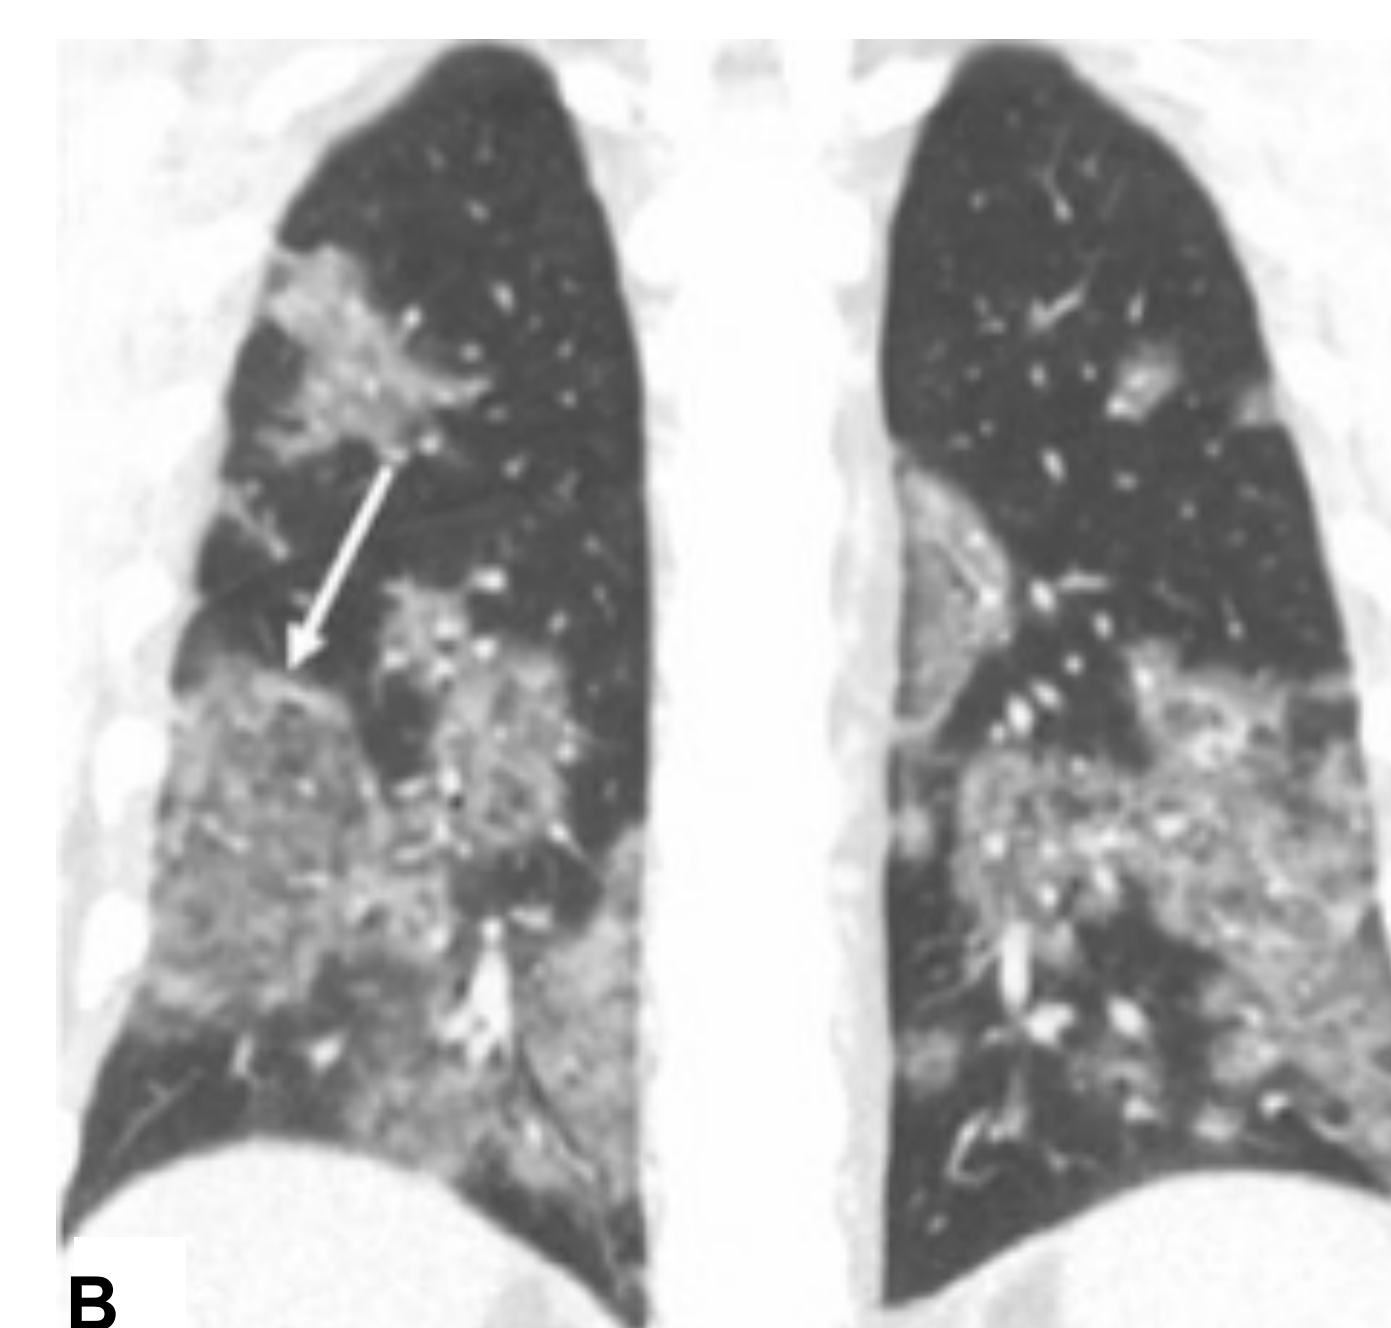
Chest CT in the coronal plane demonstrating with the white arrow the ground glass opacities (GGO) and septal thickening (Bhat et al., 2020, p. 299).
